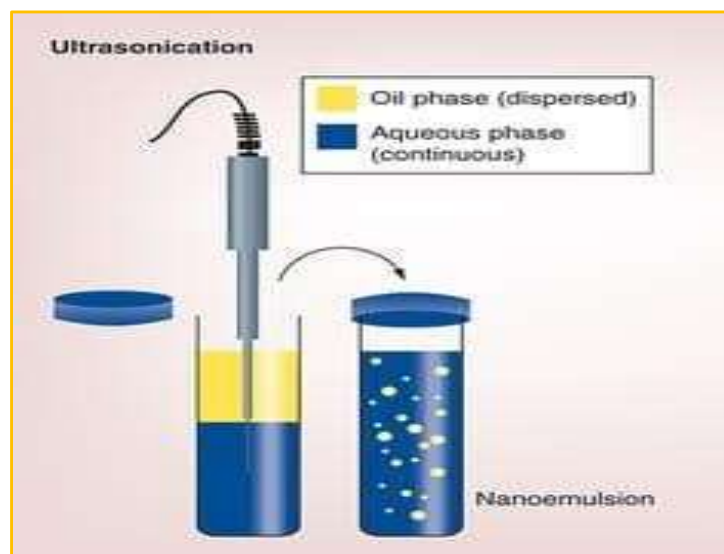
The reaction of ultrasonication approach.
